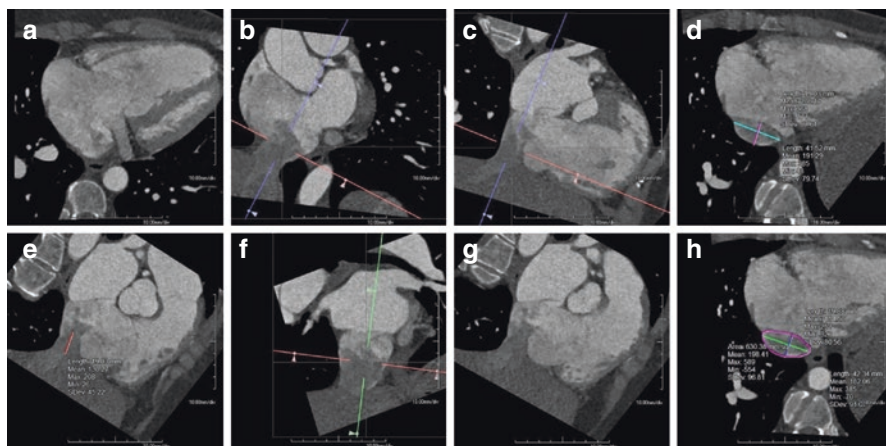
Vena Cava dimensions assessed through computed tomography. Computed tomography assessment of the inferior vena cava (IVC) dimensions using the Orthogonal axial view (a), single oblique sagittal view (b, f) and the Coronal view (c, g). In order to reconstruct a transverse plane of the entrance of the IVC into the right atrium (d), multi-planar reformation planes were aligned along the transition of right atrium and IVC. Panel (e) depicts the distance between the first hepatic vein and the IVC. The maximal and minimal diameter, perimeter and area of the IVC are measured in h, using a double oblique transverse plane
